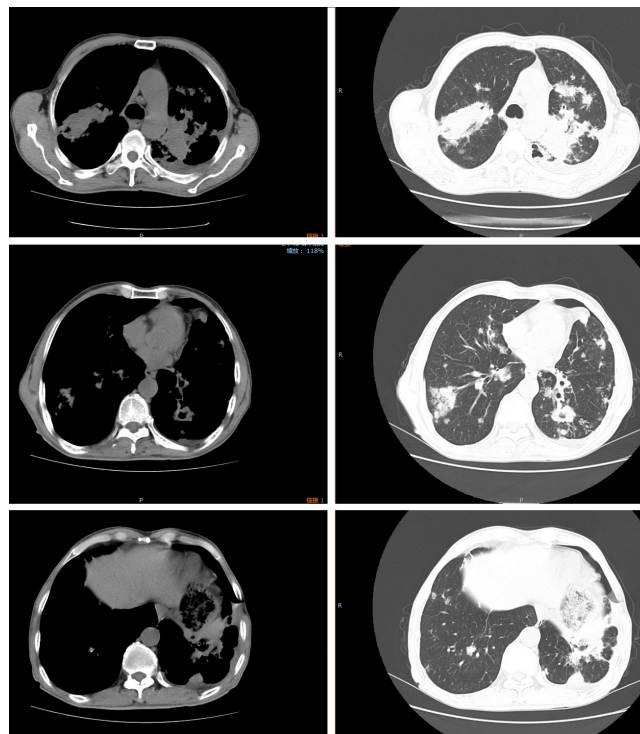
Typical images of upper, middle and lower lung from the patient's first chest CT done at Outpatient Department, 3 days before admission
